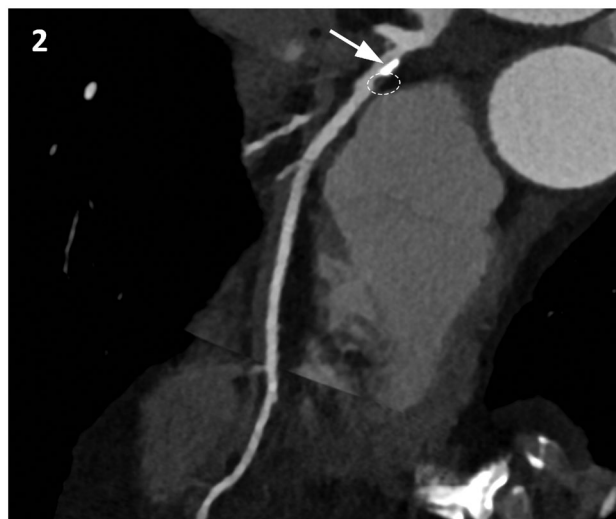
Computed tomography coronary angiography images with curved multiplanar reconstruction and segmental vessel analysis of the left anterior descending artery. Visualisation of a mixed coronary atherosclerotic lesion with an extensive calcification (arrow) and a soft plaque (circle).
